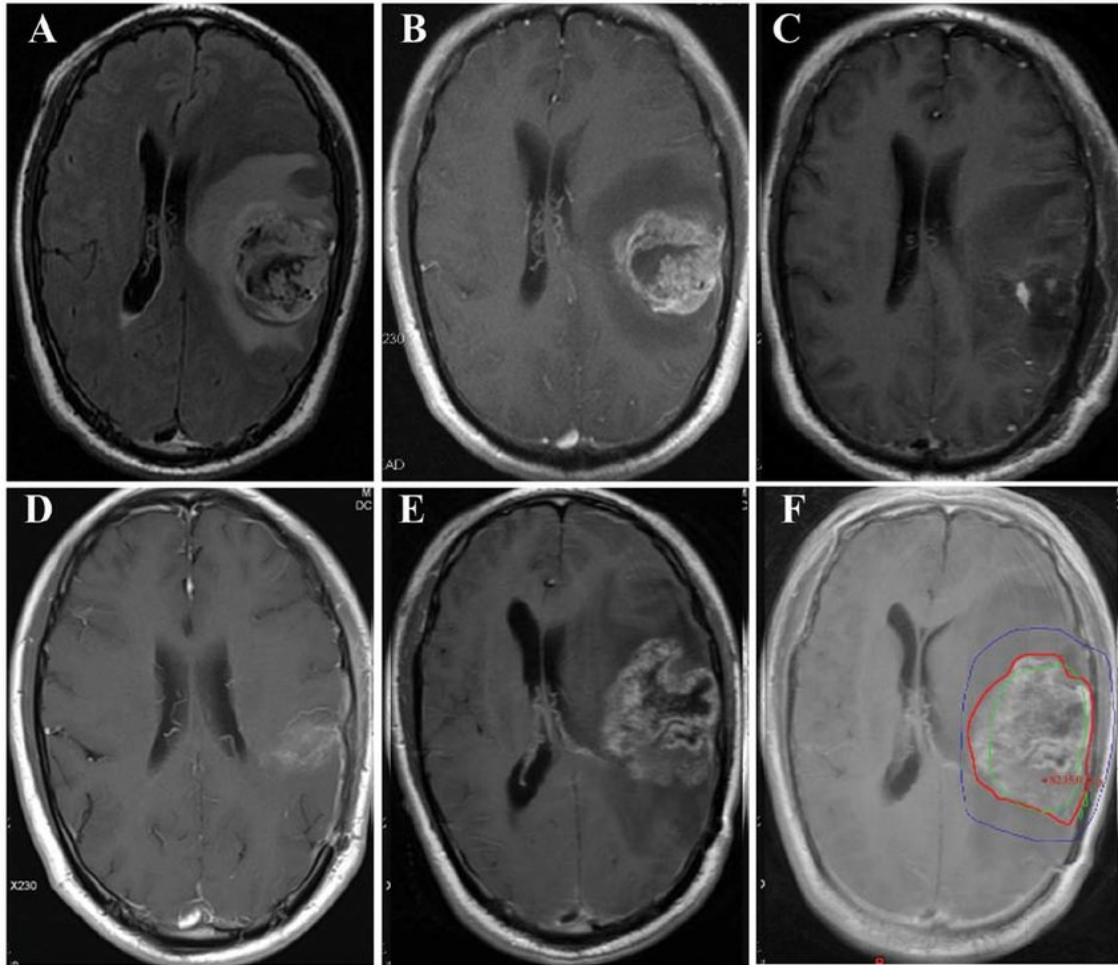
MRI scan images of glioblastoma multiforme (Image taken from [20])
